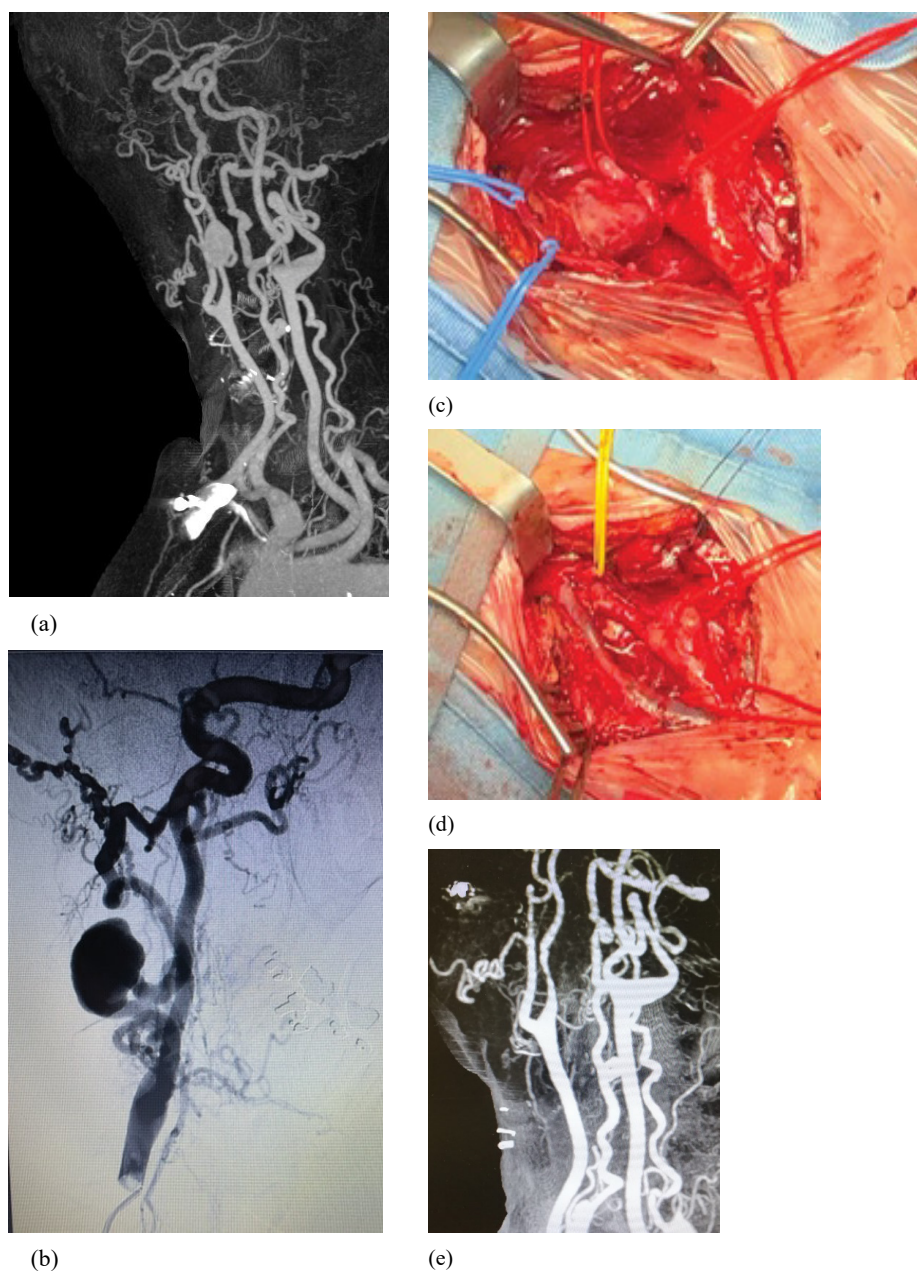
(a) Preoperative CT angiography; (b) Carotid angiogram; (c) ICA aneurysm; (d) Aneurysm resection and ICA reconstruction; (e) Postoperative CT angiography.
